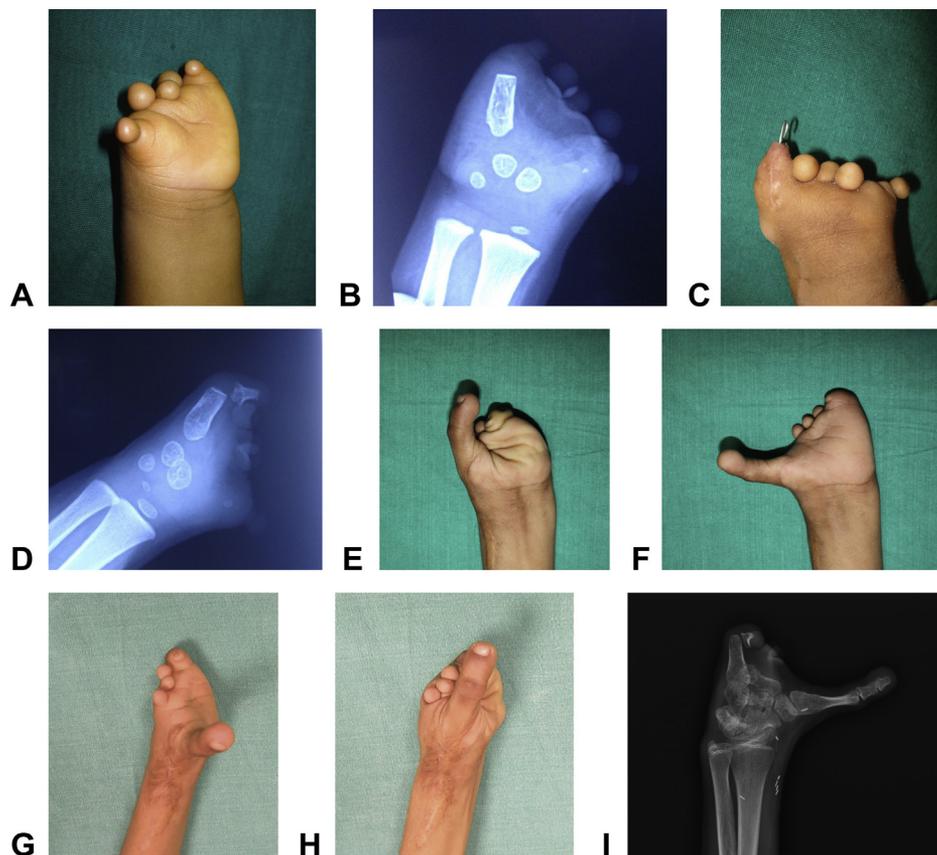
A Symbrachydactyly with the presence of only the fifth metacarpal. B Radiograph. C Nonvascularized free toe phalangeal transfer to augment the ulnar post. D Postoperative radiograph showing the bone graft, where the graft is flexed into the palm. E–H Following the second toe transfer. I Radiograph showing the survived phalanx 11 years after the free toe phalanx surgery and 8 years after the toe transfer, when the child was 13 years old.
